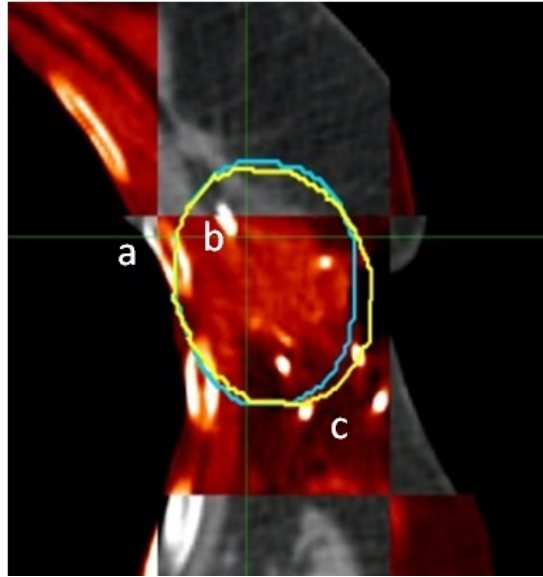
Fusion of the planning (gray) and day-0 (red) images after rigid registration based on the volume inside of the ROIs (yellow and blue). The position of a rib (a) is observed to have good agreement between the images. The location of a surgical clip visible in both images (b) within the ROI is nearly identical in the registered coordinates. The bright spots within the day-0 image (c) represent the implanted seed positions, and therefore do not appear in the planning CT.
